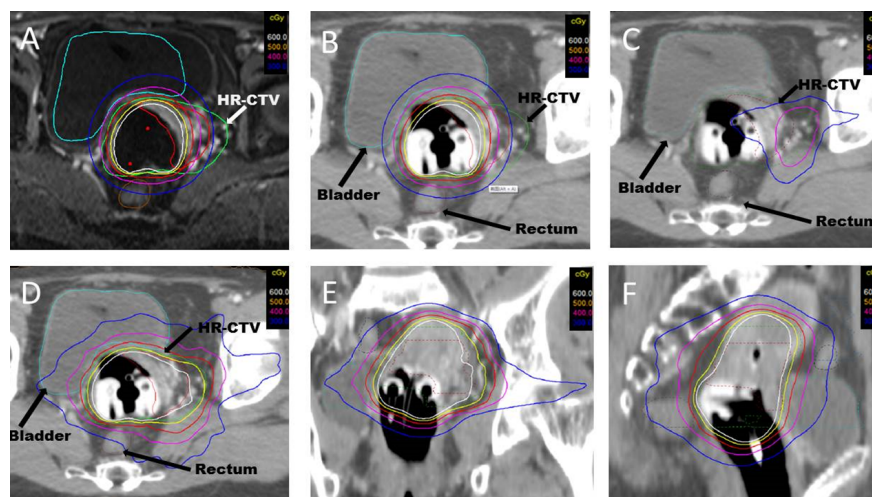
The HR CTV contouring with no filling on MRI (A), A sample dose distribution from intracavitary brachytherapy (ICBT) (B), IMRT supplement dose (C), B+C plan for one fraction in (D) cross section, (E) sagittal and (F) coronal planes.
